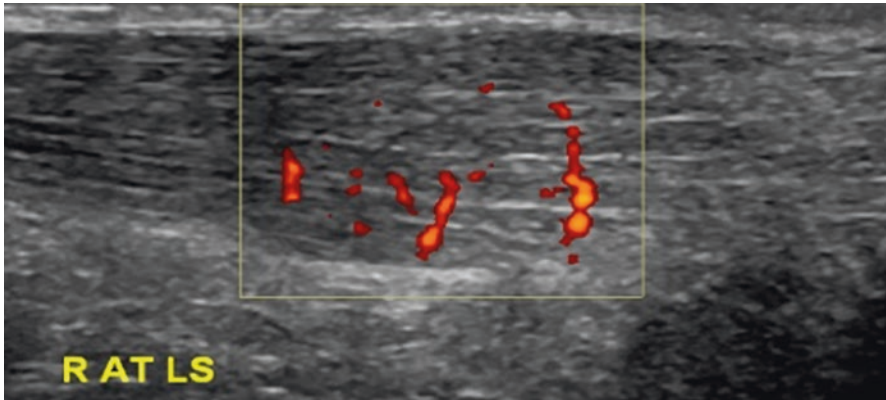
Longitudinal ultrasound image of the Achilles tendon (proximal on the left, distal to the right). There is severe, chronic midportion Achilles tendinopathy with fusiform thickening, hypoechoic fibrillar echotexture, and neovascularity. This represents grade 4 on the modified Ohberg scale with at least four vessels running through the substance of the tendon [17]
